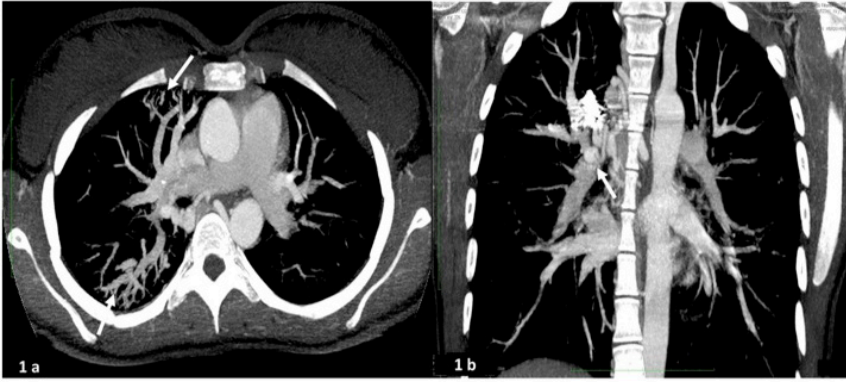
Thoracic angio-CT scan at admission shows: presence of multiple AV Fistulas of RUL and RLL, increase of pulmonary venous and right bronchial artery and its branches caliber associated to aneurismatic dilatation of 1 cm. Web-like appearances are evident in the superior segment of RUL. Transversal (a) and Coronal (b) view.
